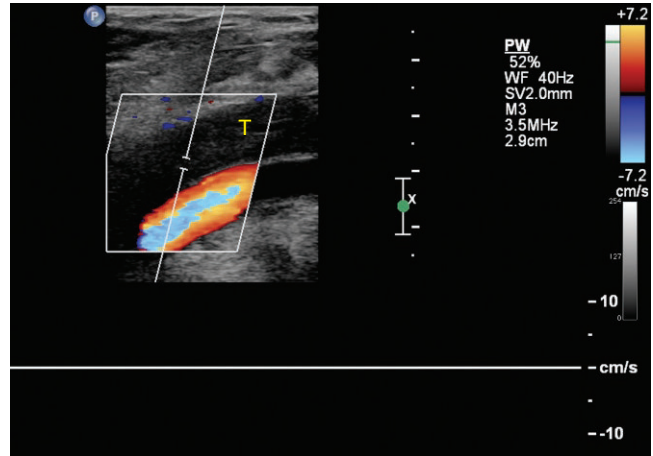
In a different patient who presents with acute swelling of the leg, acute deep venous thrombosis was present (T). The thrombus is completely occluding the vein and there is no flow by color or spectral Doppler.
